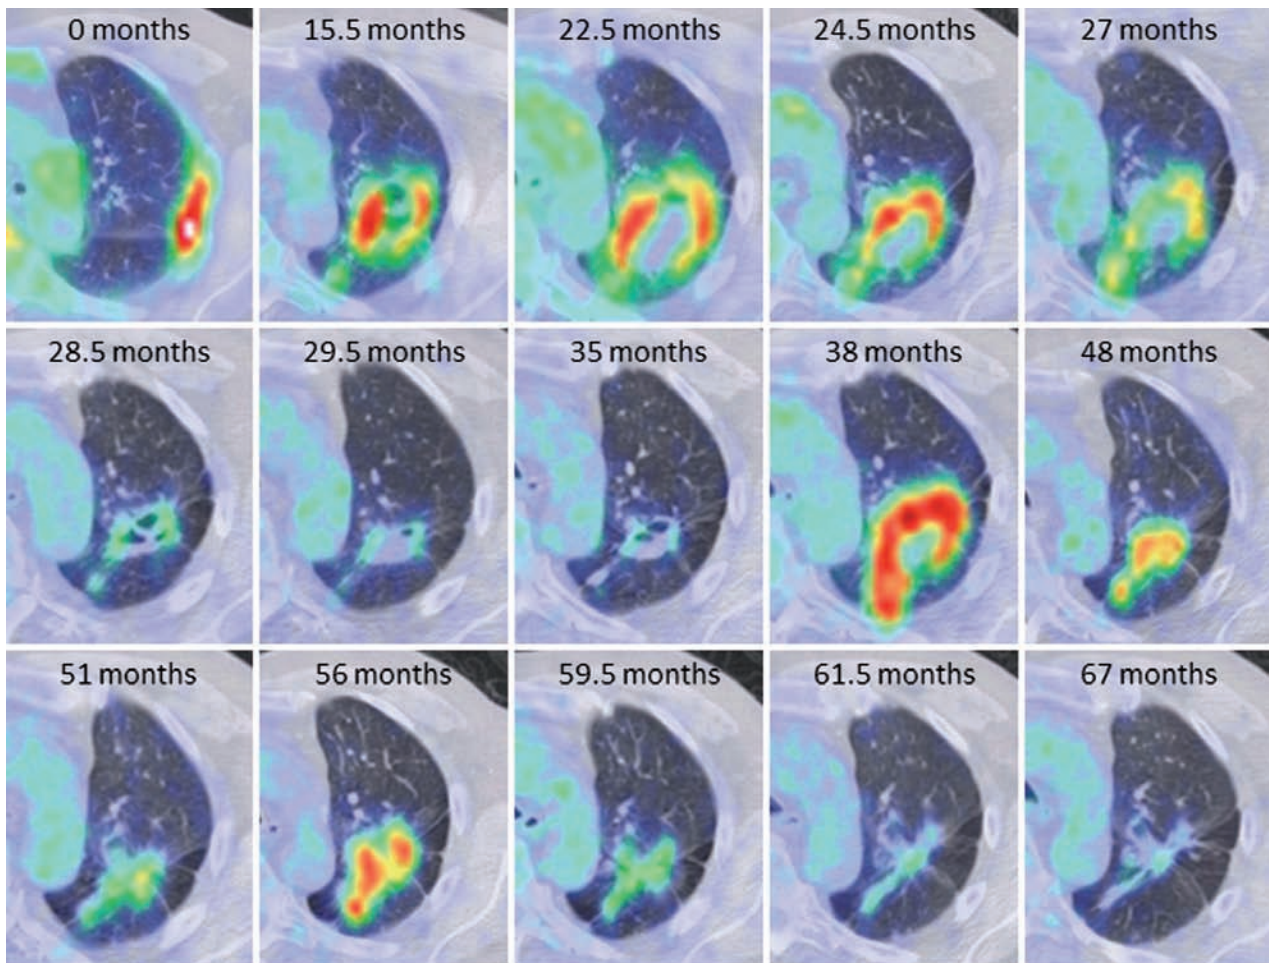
Following GPA in FDG PET/CT in a cancer patient. GPA in the left upper lobe that was twice biopsy proven shows the how FDG activity seen on PET and the changes on CT complement each other in assessing the response to therapy and subsequent flairs of GPA over time. All images are axial PET/CT. This patient (no. 9) had recurrent metastatic melanoma in the neck, and the PET/CT scans were performed primarily to follow the melanoma. At 28.5 months since his initial PET/CT, right neck lymph nodes were increasing in FDG activity, as opposed to the decreasing activity in the known GPA in the lung, and these nodes proved to be recurrent melanoma. At 48 months, a focus of FDG activity was identified in the colon that was increasing in activity, again as opposed to the decreasing activity in the known GPA in the lung at that time, and the colon lesion proved to be an incidental primary colon adenocarcinoma. Therefore multiple FDG PET/CT scans over time can help to follow cancer and GPA, and at times can help to differentiate between the two. However, as exemplified in figure 1, in a given lung lesion on a single scan, neither FDG PET/CT nor diagnostic CT can confidently differentiate between active GPA and cancer
